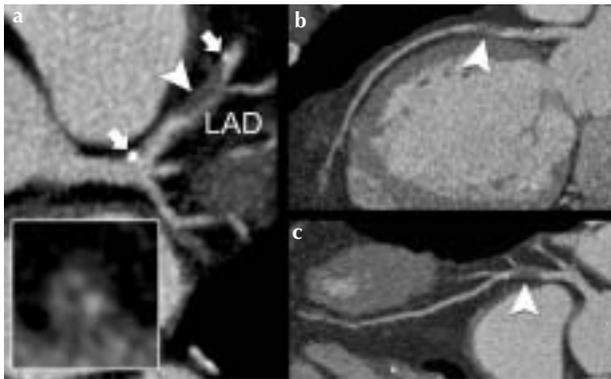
(a) Maximum intensity projected and (b, c) curved multiplanar reconstructed computed tomography images, confirming the presence of the coronary lesion in the left anterior descending coronary artery (LAD) (arrowhead), and providing information regarding both the coronary lumen and the underlying plaque. Clearly visualized: noncalcified plaque (gray) at the level of the coronary lesion has two small calcified plaques (arrows) proximal and distal to it. Inset: Cross-sectional image at the level of the noncalcified plaque, providing more detailed information of the coronary lumen and adjacent noncalcified plaque tissue.
